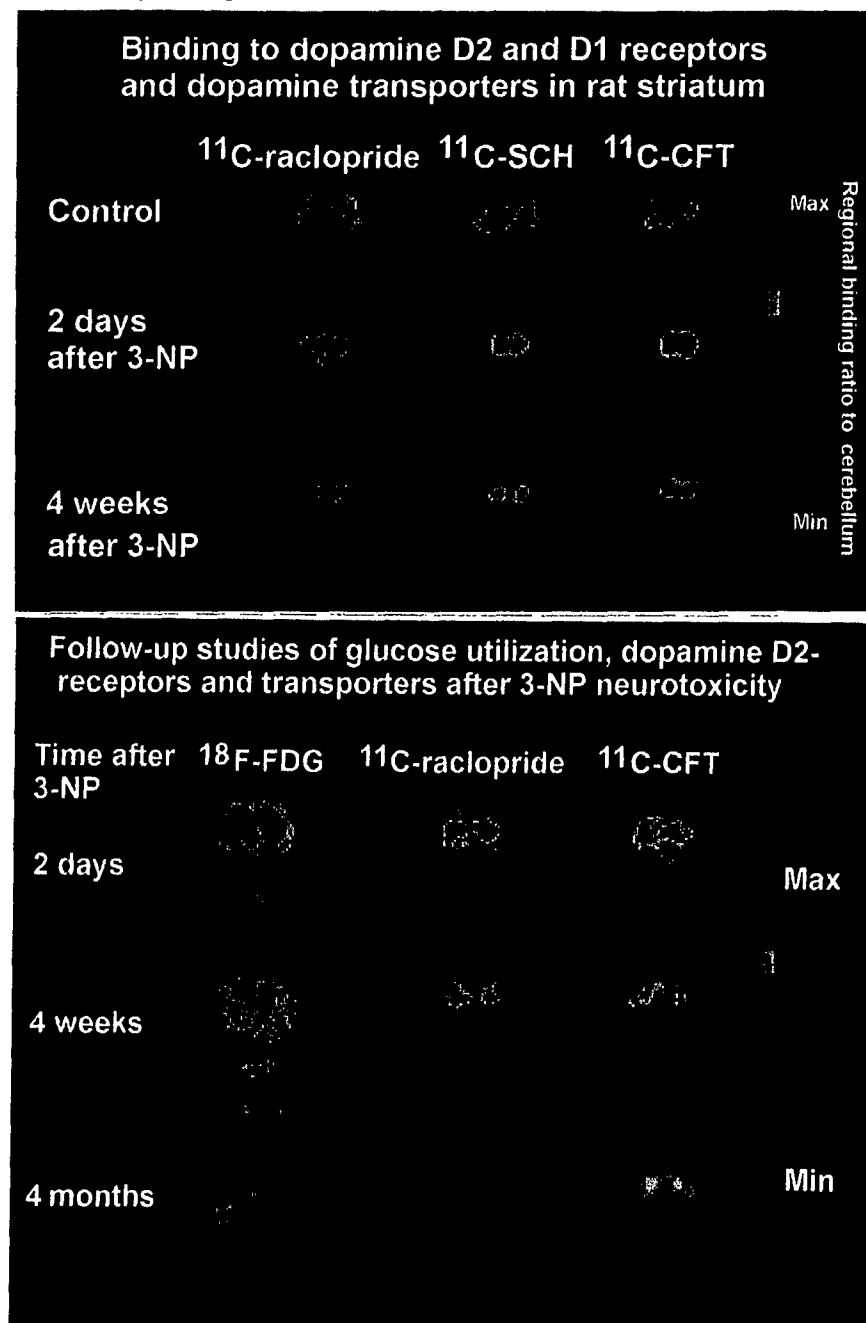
Longitudinal PET studies of glucose utilization (^{18}F -FDG), dopamine D2 receptors (^{11}C -raclopride), dopamine D1 receptors (^{11}C -SCH) and dopamine transporters (^{11}C -CFT) pre and post 3-NP. Note the local decrease of glucose utilization in striatum in 2 days after 3-NP and late recovery. Dopamine D1 and D2 receptors show gradual decrease in binding while dopamine transporter shows first enhanced binding and later decrease.
